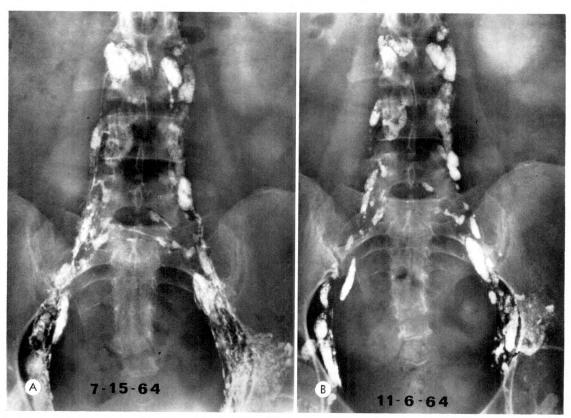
(A and B) Frontal roentgenograms of the abdomen and pelvis before and after irradiation. Note slight reduction in the size of the lymph nodes.
